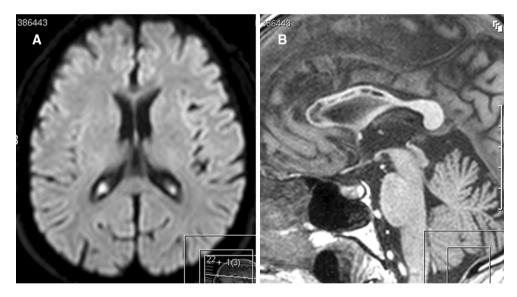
a Twelve days after symptoms onset, DWI shows a reduction of hyperintense signal in the entire corpus callosum. b T1-weighted sagittal imaging shows cystic degeneration areas in the corpus callosum
